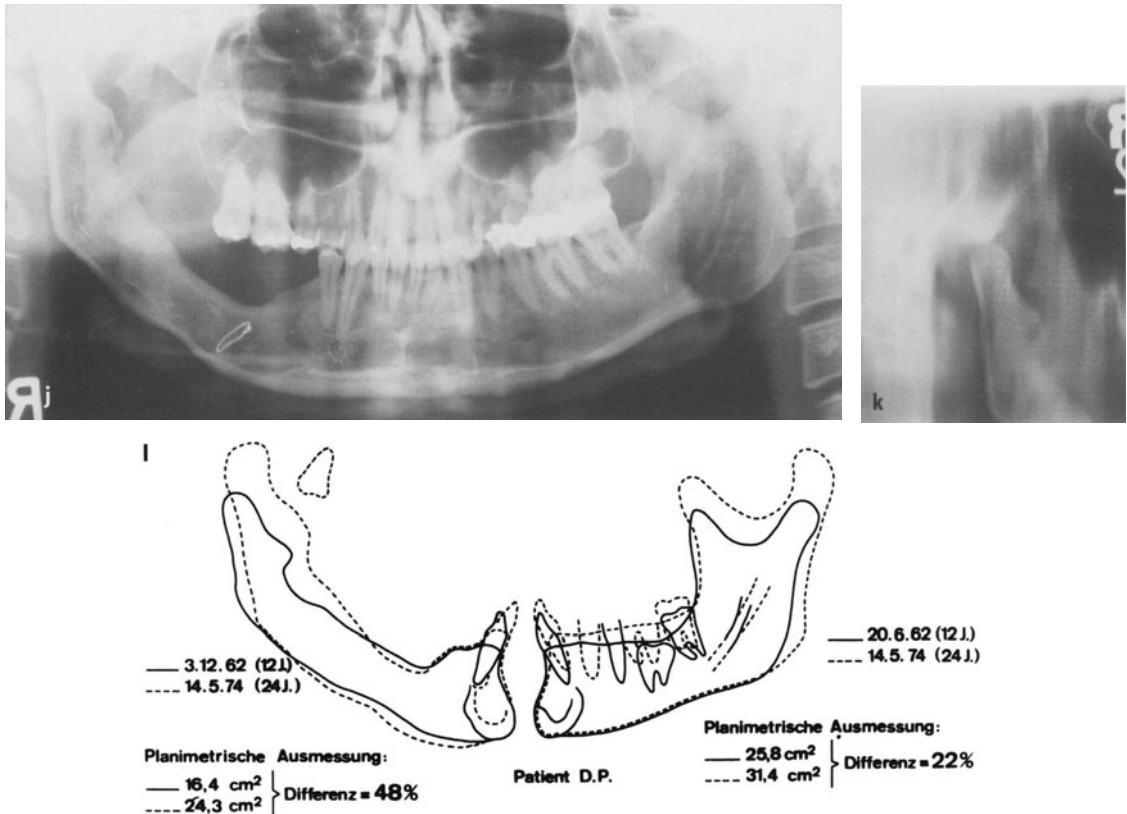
Normal growth of an iliac crest graft replacing the ascending ramus with the condyle and half of the body in childhood. j, k Radiographs taken 12 years after surgery: the iliac crest graft was contoured with a condyle-like end. It moves forward to the articular prominence, probably due to scar healing of the coronoid process to the iliac crest graft. l A comparison of the tracings of the two halves of the mandible 2 years and 12 years after surgery discloses clearly that the graft has grown more in length and volume than has the normal side of the mandible (by courtesy of H. Sailer)
